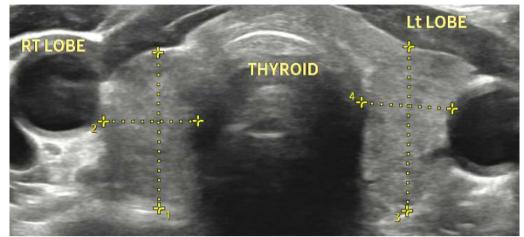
Ultrasound image of thyroid gland showing diffusely heterogeneous echotexture with small hypoechoic areas- Diffuse thyroiditis pattern
